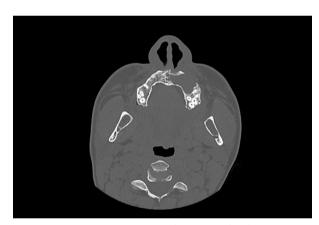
Preoperative computed tomography demonstrates the cystic lesion on the left side of the maxilla.
